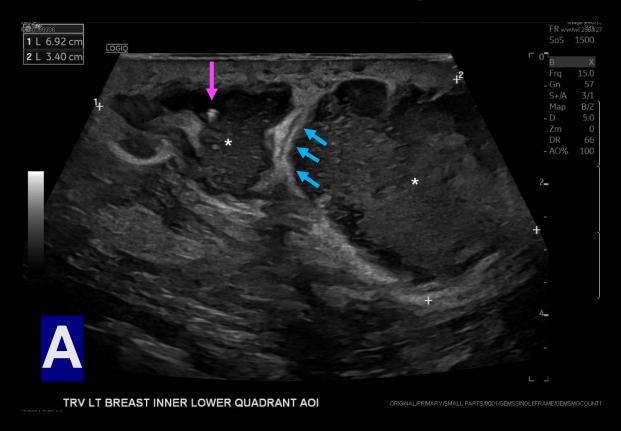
Figure A Transverse ultrasound of left breast. Thick-walled, complex, multiloculated fluid collection with thick intervening septa (blue arrows) and heterogenous internal echoes (asterisks). Lesion measures 7 x 3.8 x 3.4 cm, with a focal area of echogenicity consistent with a post-biopsy clip (pink arrow).
